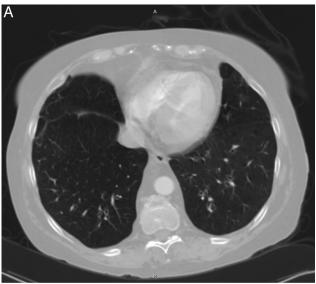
Chest computed tomograms from the base (A) and apex (B) of the patient's lung, suggesting disproportionate emphysematous involvement of the base, compared with the apex. This pattern was born out by a densitometric analysis in which the percentage of pixels with densitometry < -900 Hounsfield units (indicating emphysema) showed a greater proportion of emphysema at the base than at the apex.
